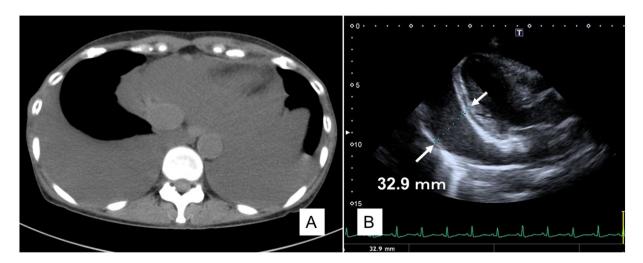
Computed tomography and echocardiography findings. (A) Computed tomography reveals bilateral pleural effusion. (B) An echocardiogram reveals pericardial effusion (width: 32.9 mm). The patient underwent treatment with bevacizumab (15 mg/kg, every 21 days) after thoracocentesis and pericardiocentesis.
